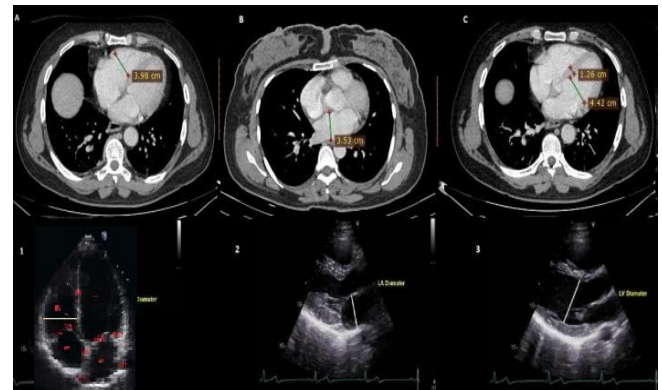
Pictorial representation of CT (Fig. A, B, C) and Echocardiography (Fig. 1, 2, 3) measurements for RA, LA and LV chambers.
